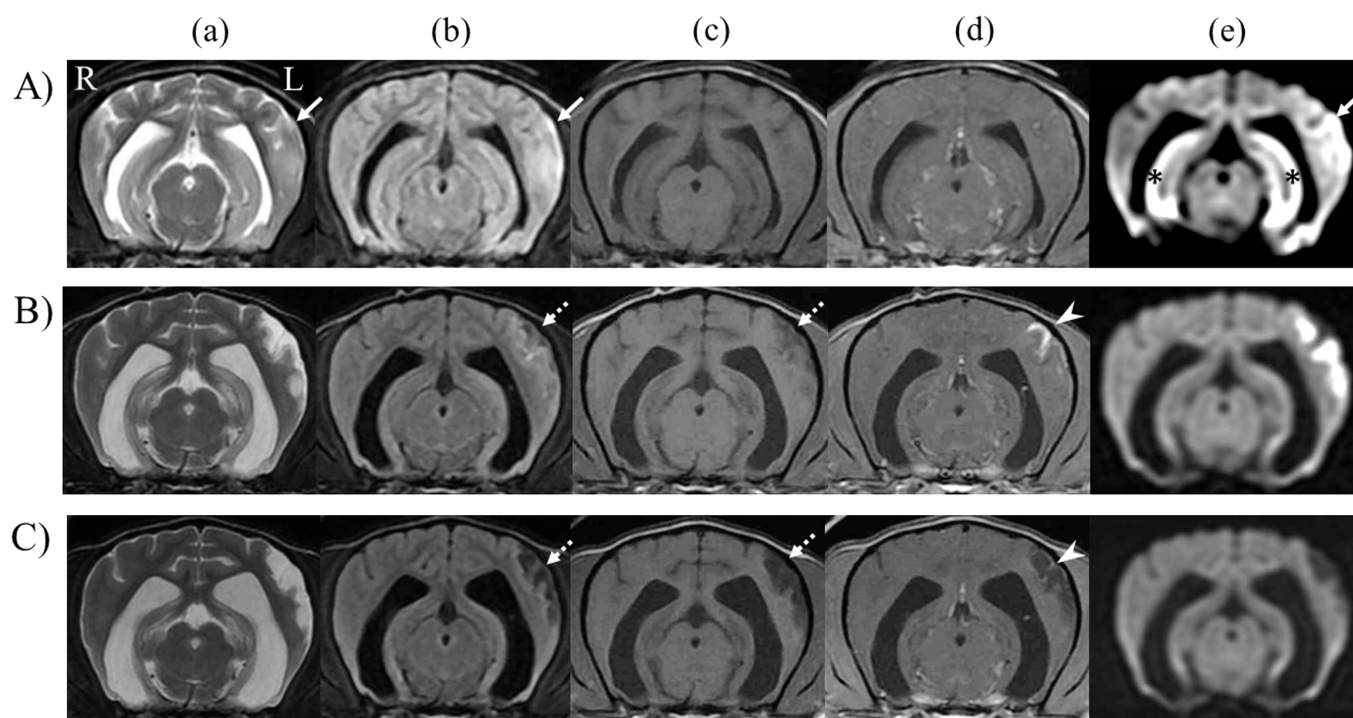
Transverse images obtained at the temporal lobe level. Images were acquired on the A) second day, B) 39th day, and C) 133rd day after the epilepsy onset by a) T2WI, b) FLAIR, c) T1WI, d) post-contrast T1WI, and e) DWI. A) On the second day after onset, T2WI, FLAIR, and DWI showed hyperintensity respectively in the left temporal lobe, including the gyrus sylvius and gyrus ectosylvius medialis (arrow). T1WI showed isointensity, which was not enhanced by contrast medium. The hyperintensity was clearer on DWI than on T2WI and FLAIR, and showed in the left temporal lobe and bilateral hippocampi (asterisk). B) On day 39 after onset, the temporal lobe showed hyperintensity on T2WI. The center of the left temporal lobe showed hypointensity on FLAIR and T1WI respectively (dotted arrow). The periphery of the temporal cortex showed hyperintensity on FLAIR, with linear contrast enhancement on T1WI (arrowhead). Hyperintensity on DWI was maintained in the left temporal lobe. C) On day 133 after onset, the center of lesion in the temporal lobe showed hyperintensity on T2WI. The lesion was observed hypointensity on FLAIR and T1WI respectively (dotted arrow). The cortex periphery was hyperintense on FLAIR, with linear contrast enhancement on T1WI (arrowhead). The hyperintense lesion in the left temporal lobe was not seen on DWI. T1WI, T1-weighted imaging; T2WI, T2-weighted imaging; FLAIR, fluid attenuated inversion recovery; DWI, diffusion-weighted imaging; L, left; R, right.
